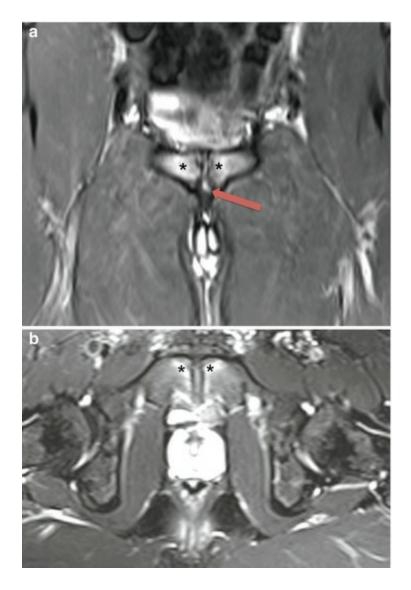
A 25-year-old male athlete with pubic bone marrow edema and "secondary cleft sign", presenting with a 10-weeks history of left groin pain. (a) Coronal and (b) axial short tau inversion recovery MRI show bilateral anterior pubic bone marrow edema (*asterisks*) and linear hyperintense signal along the anteroinferior margin of the left pubic tubercle (*arrow*), consistent with secondary cleft sign
